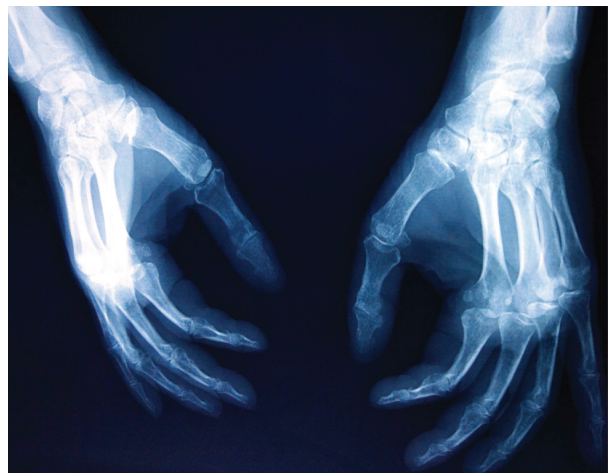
X-ray of both hands showing normal findings
